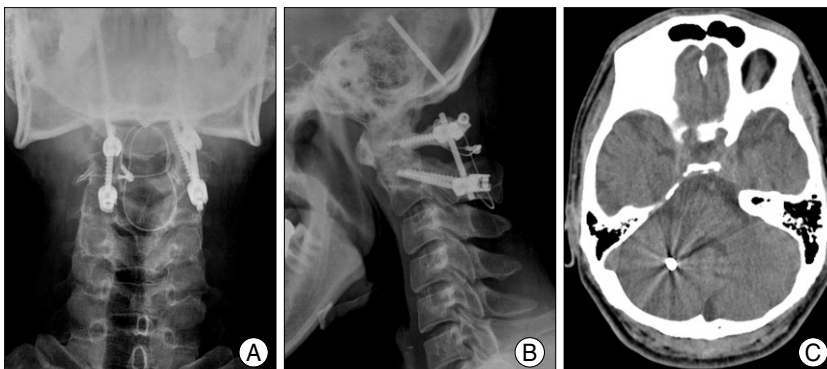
On 20 months after surgical procedure, the patient complained of headache and dizziness. Head computed tomography scan (A) and cervical X-rays (B and C) show migrated rod into the cerebellum.
